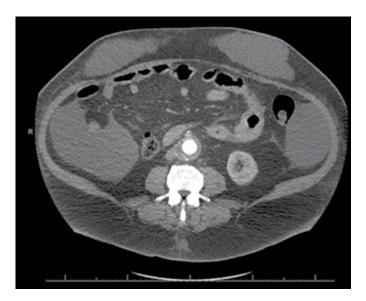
Enhanced computed tomography scan of the abdomen six weeks postoperatively showing reaccumulation of ascites in spite of the per-cutaneous drainage.
